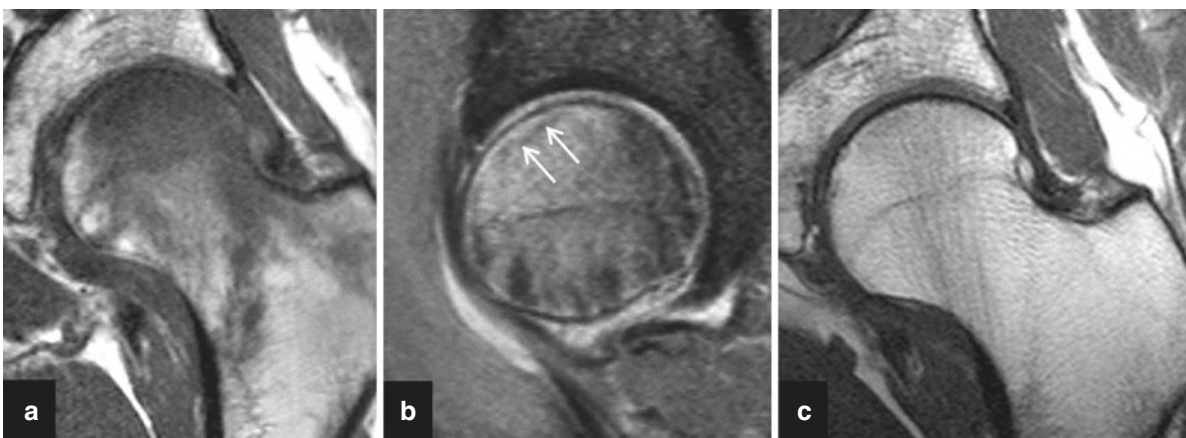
Subchondral insufficiency fracture of the femoral head in a 57-year-old man. (a) Coronal T1-weighted MR image of the left hip demonstrates extensive ill-delimited bone marrow edema-like signal changes in the proximal femur that predominate in the subchondral
